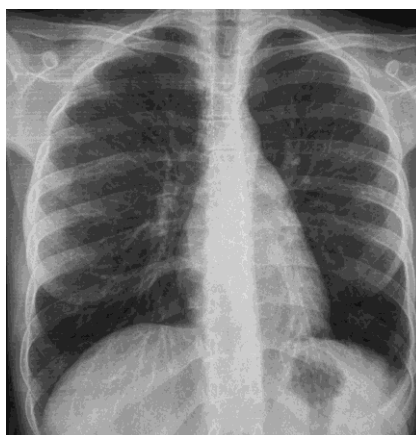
Frontal chest X-ray showing clearing of the left basal opacity.
